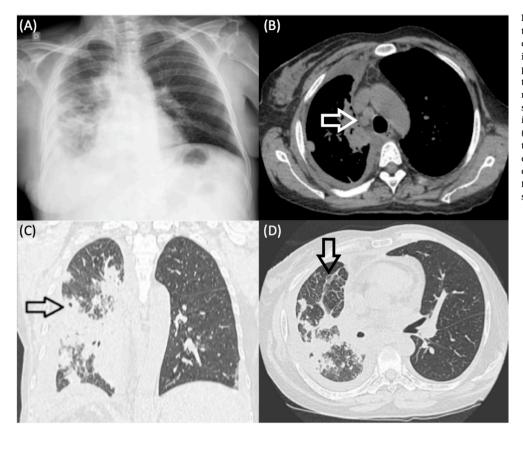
Radiological findings in the liver transplant recipient with Paracoccidioidomycosis. A: chest X-ray displaying right pleural effusion associated with poorly delimited and diffuse alveolar opacities, preserving only the periphery of the right upper lobe, whereas the left lung showed preserved radiolucency. B: axial image from chest computed tomography (CT) displaying enlarged hilar and paratracheal lymphadenopathy (arrow). C: coronal image from chest CT showing a cavitated nodule (arrow). D: axial image from chest CT highlighting the inverted halo sign (arrow).
